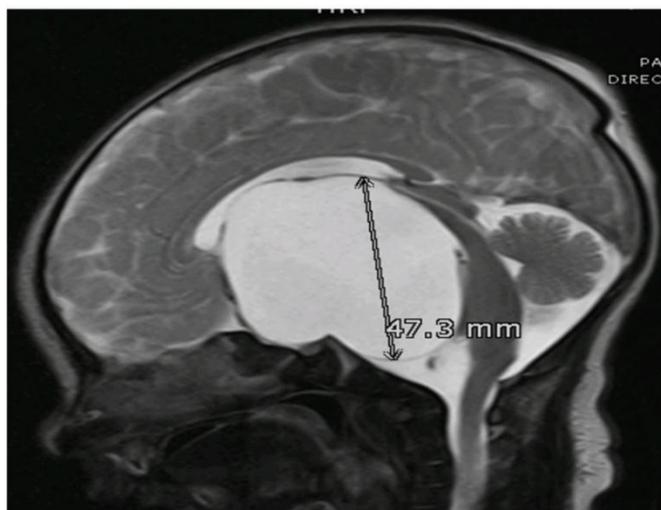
MRI T2WI, Sagittal Section (fig 2)
